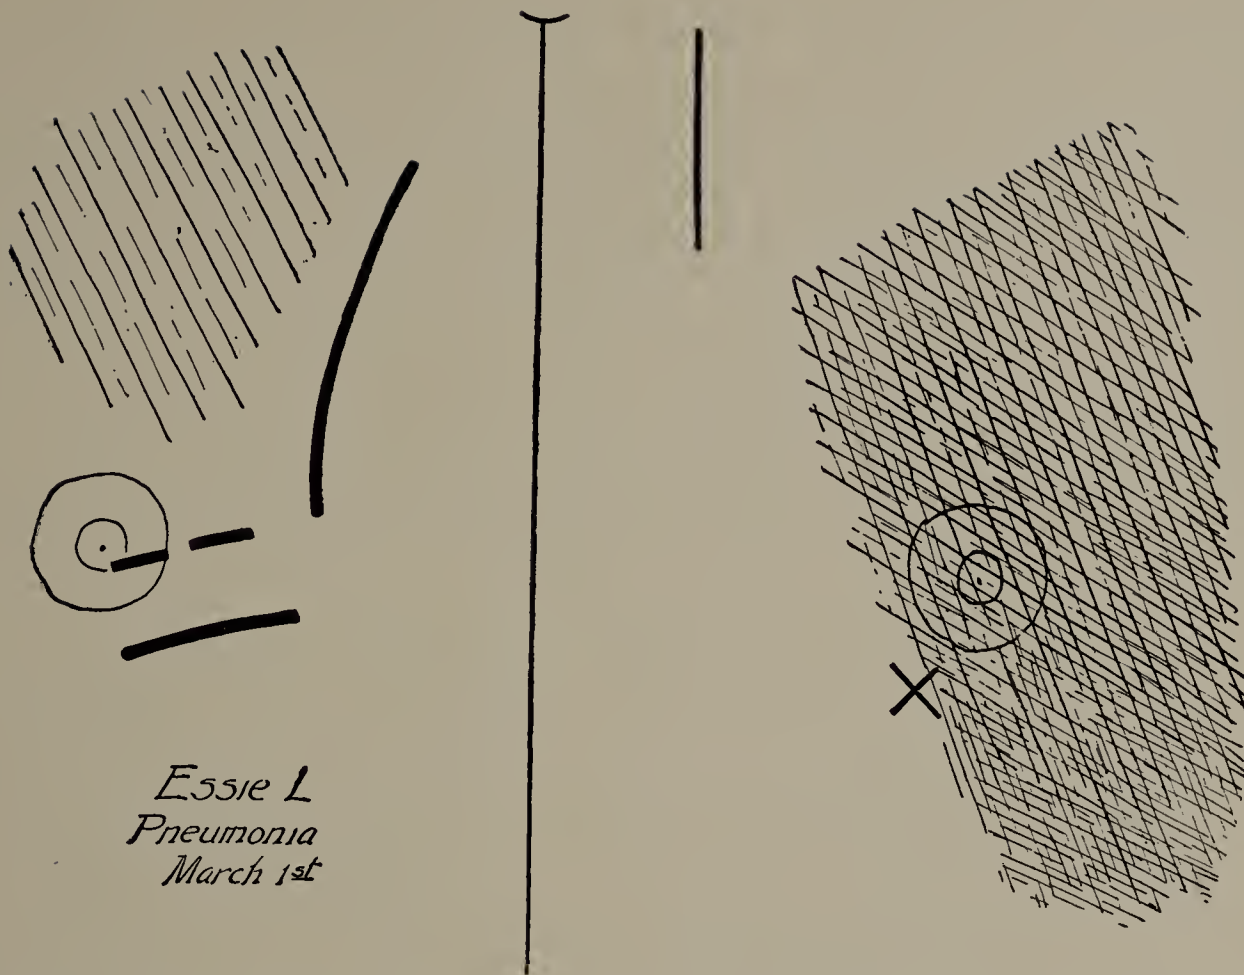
Essie L. March 1. First X-ray tracing. Pneumonia, left side. Darkened left lung. Right border of the heart farther to right than normal. (One-third life size.)
